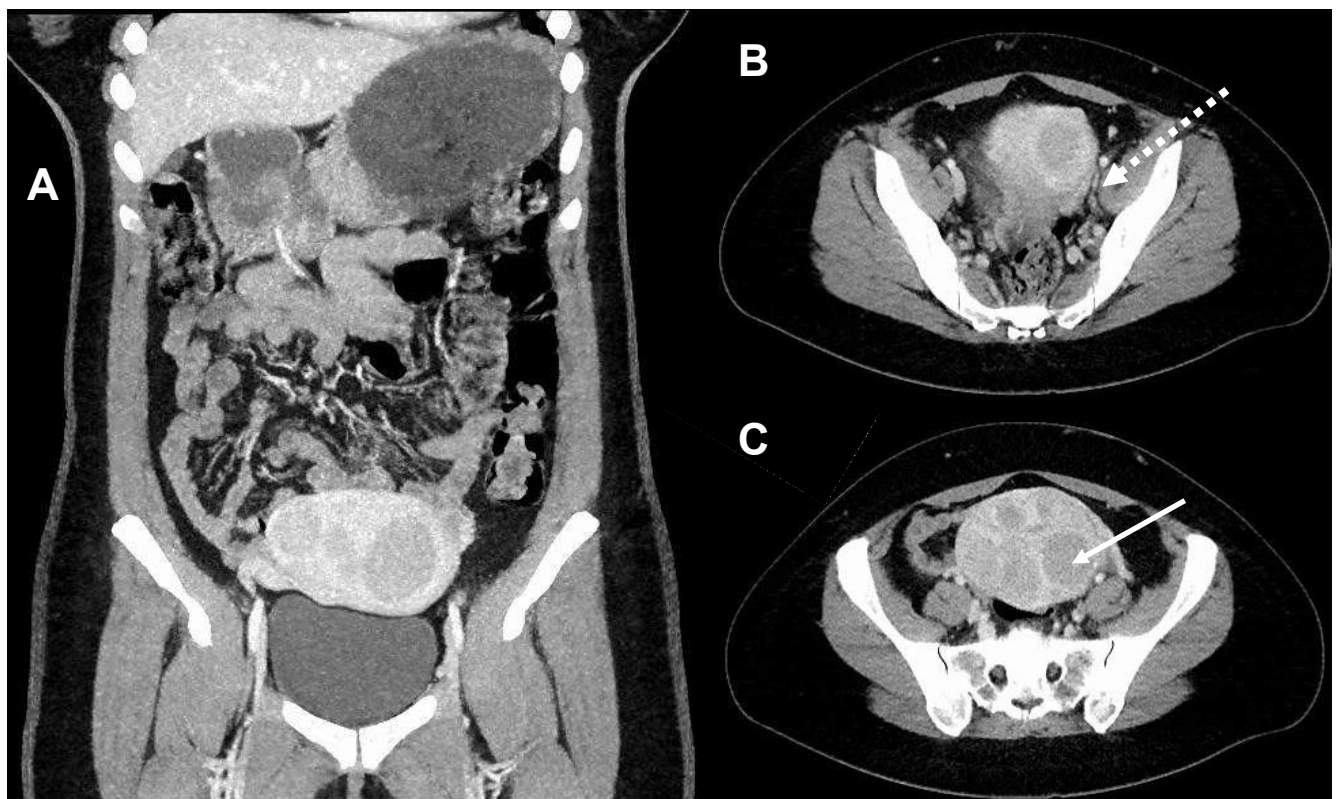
A) Coronal CT fibroid uterus, with diffuse fibroids throughout the fundus B) Axial CT, the external iliac vein on the left is compressed by the fibroid uterus, though it is still patent (dashed arrow), C) Axial CT showing fibroid uterus diameter (12cm) and highlights the largest of fibroid (white solid arrow), which measured 3.8x4.7x4.4cm
